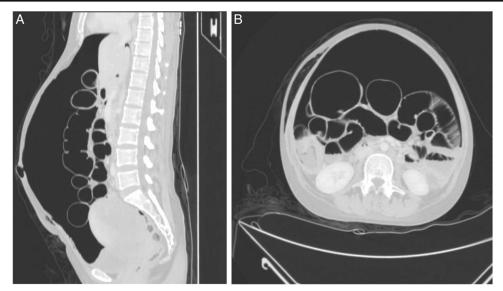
Computed tomography of the abdomen and pelvis showing a huge pneumoperitoneum and dilatation of bowel loops.
